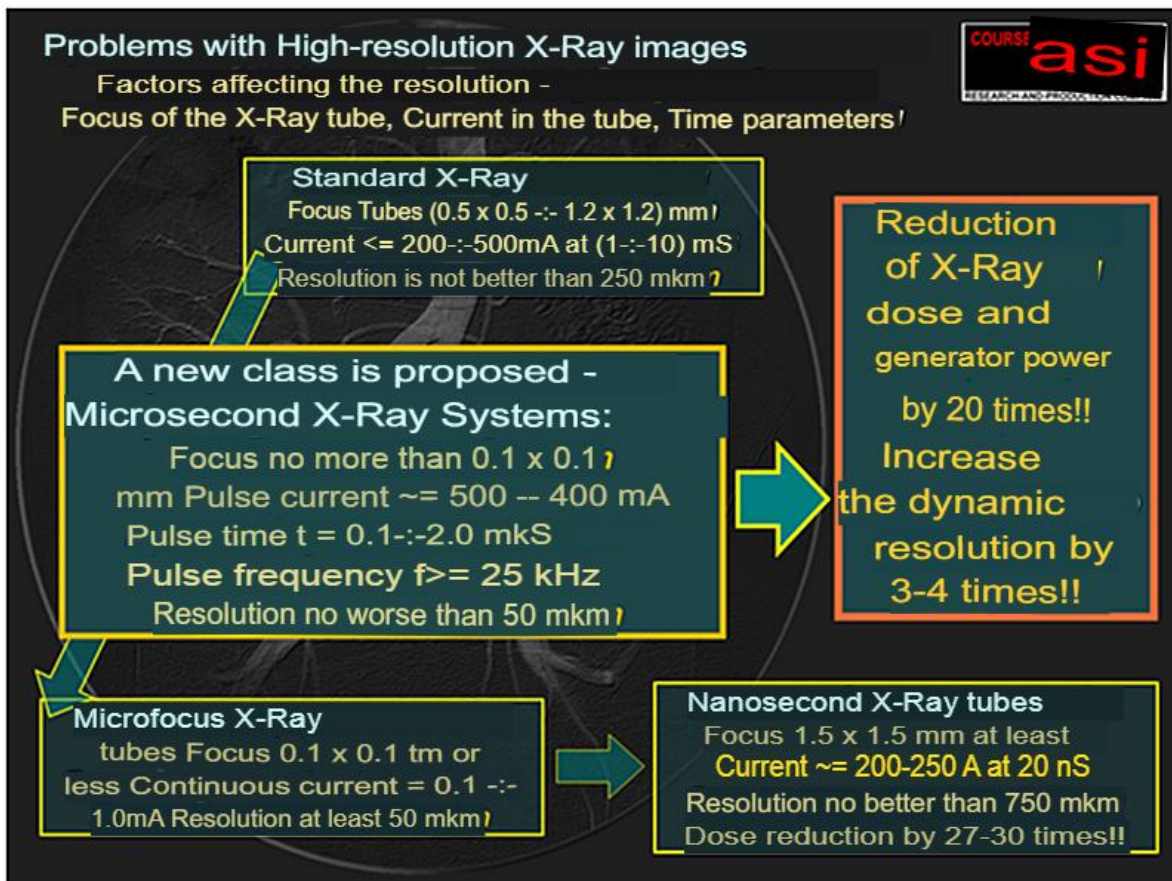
Stages of creating radiography by type of technology used.
